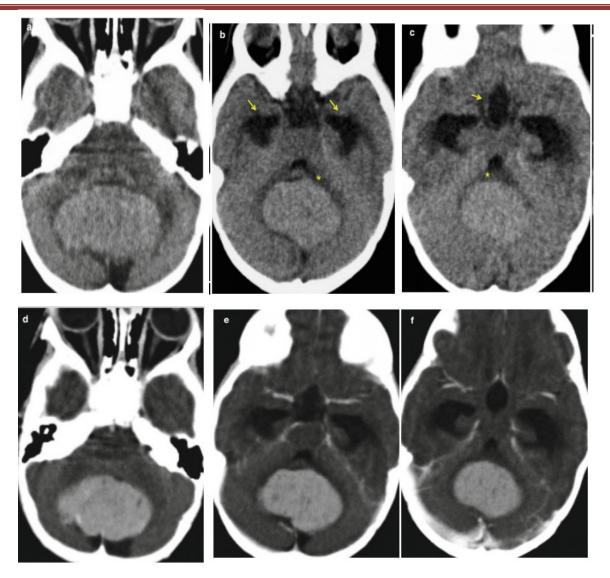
<u>Typical features of head CT scan:</u>
